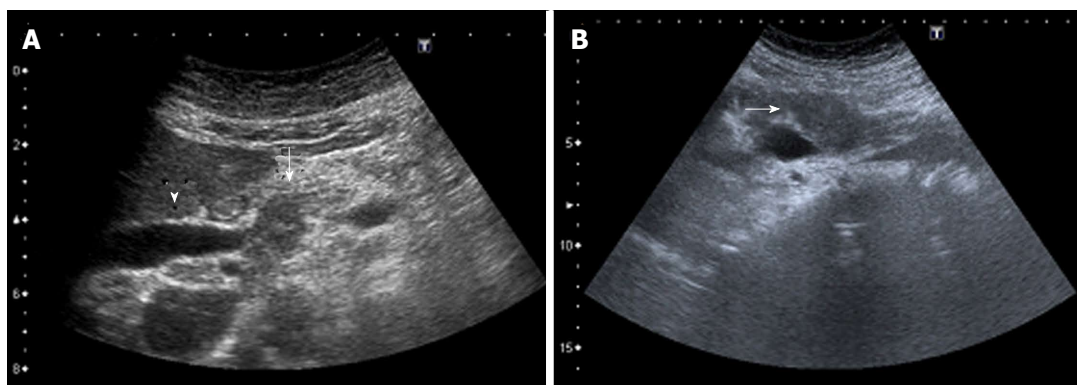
Ultrasound images (A, B) of an ill-defined, heterogeneous hypoechoic mass (arrow) in the pancreas obstructing the common bile duct (arrow-head).
